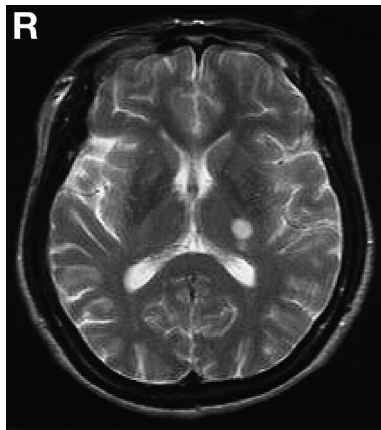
Axial T₂-weighted magnetic resonance image revealing a hyperintense area in the left thalamus.
